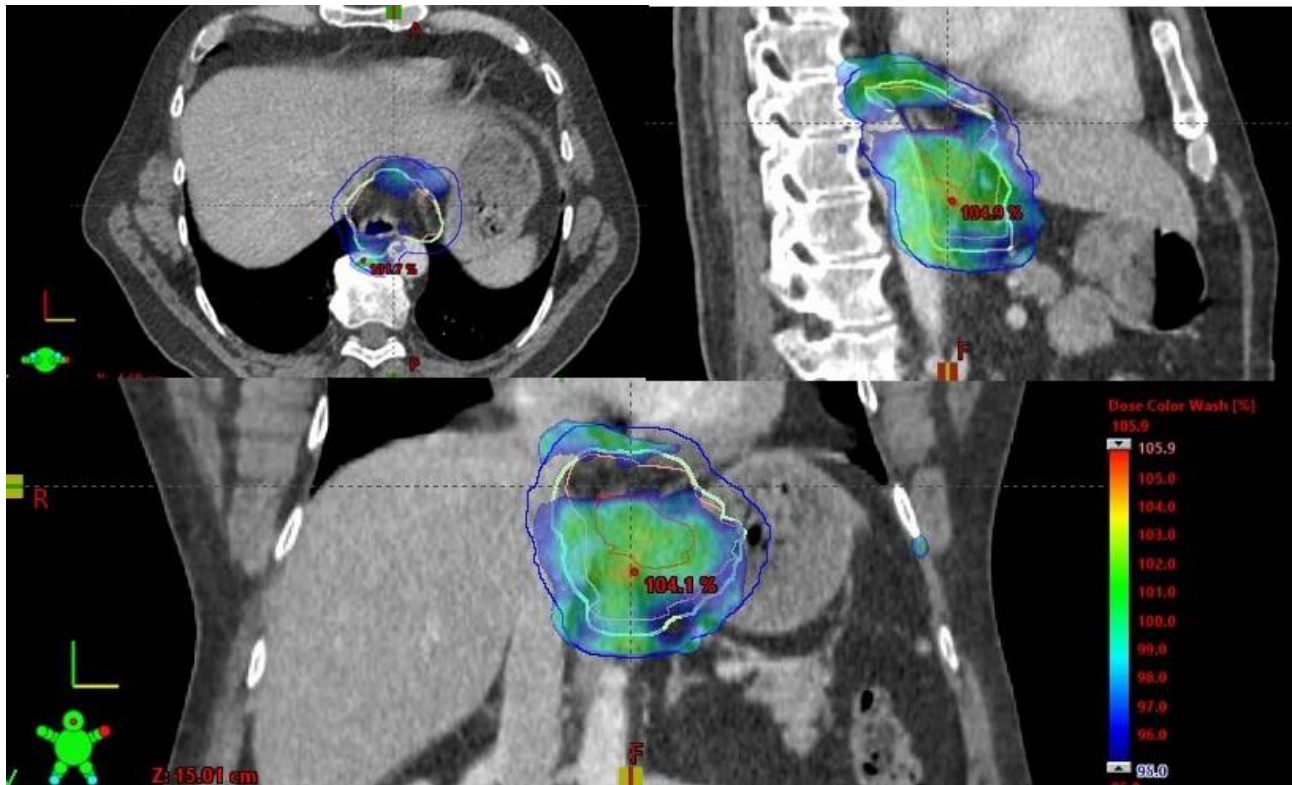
Example of a patient with insufficient coverage of the internal clinical target volume (light green) observed on the first weekly surveillance 4D-CT scan.
